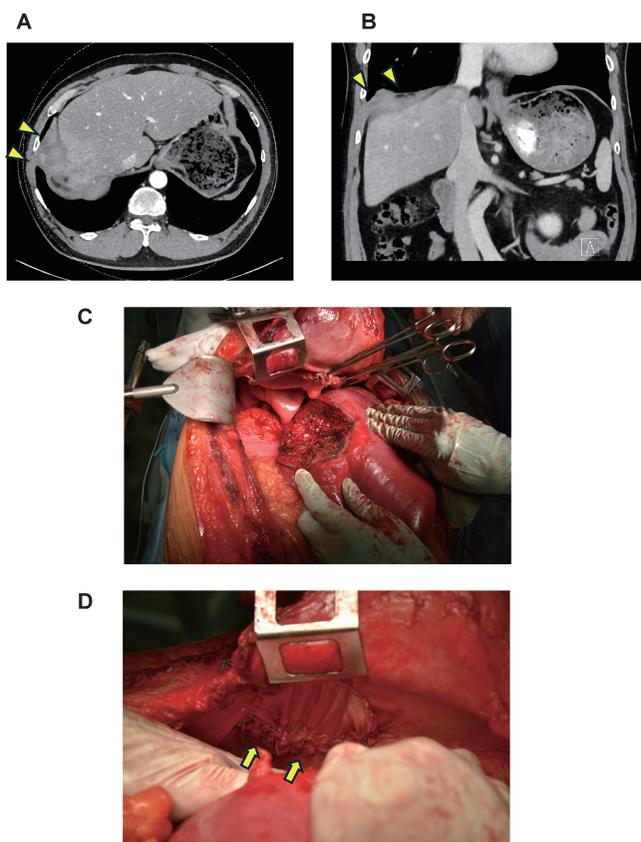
A case of a right-sided diaphragmatic inflammatory tumor involving the liver dome. Axial (A) and coronal (B) computed tomography images indicate a tumor involving the liver dome (arrowheads). The tumor was resected with a wide portion of the diaphragm and the partial liver (C). The large defect of the diaphragm was patch-repaired using the fascia lata (arrows; D).
